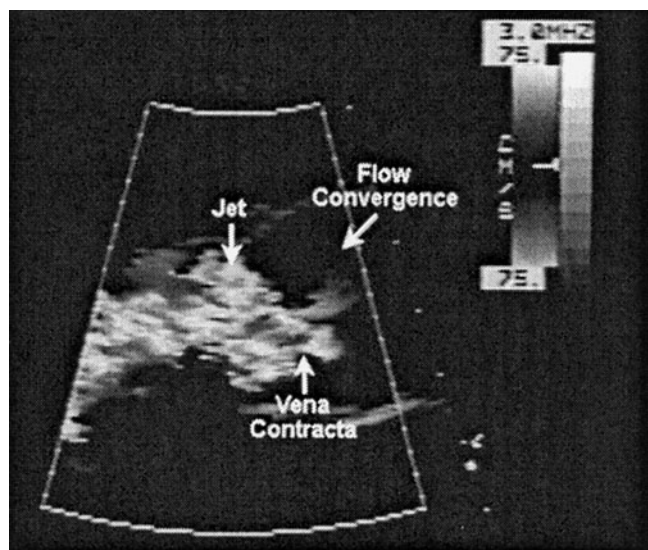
Parasternal view of aortic regurgitant flow used to delineate and measure the vena contracta (narrow neck) of the aortic regurgitation.
